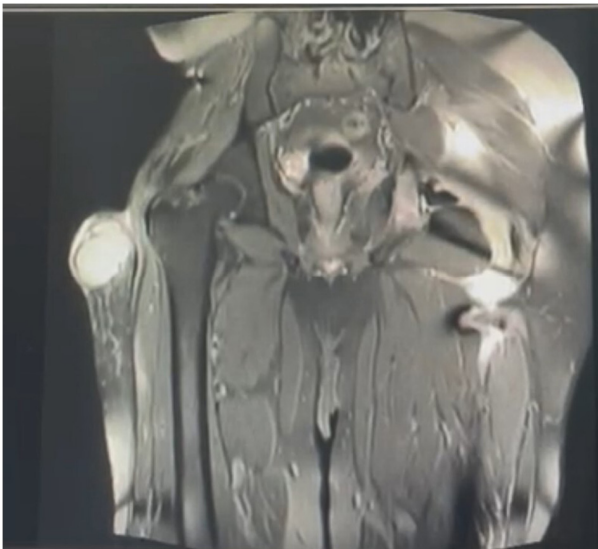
MRI coronal view of the tumor (2020). MRI, magnetic resonance imaging.
